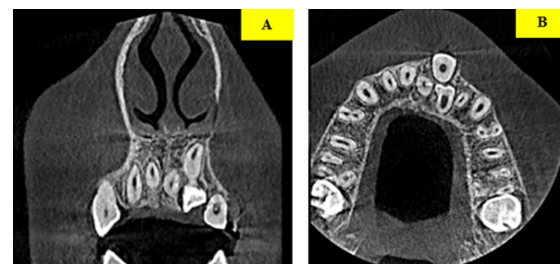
a: Coronal CBCT sections revealed multiple impacted supernumerary teeth in the anterior maxilla, one of which was inverted and located palatal to the maxillary incisors, in close proximity to the nasal floor, thereby interfering with the normal eruption pathway of the permanent incisors. 2b: Axial CBCT section demonstrates multiple palatally positioned, tooth-like radiopaque structures with independent follicular spaces in the anterior maxilla, consistent with impacted supernumerary teeth likely arising from dental lamina hyperactivity and obstructing normal incisor eruption.
